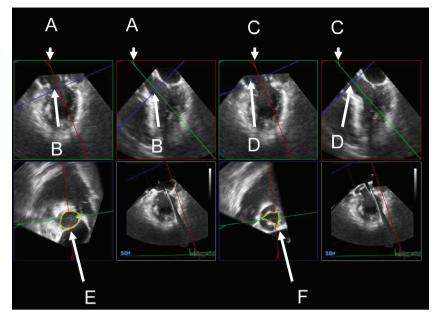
Three-dimensional transesophageal echocardiography measurements. Using a 6-beat gated, full-volume acquisition acquired with 3-dimensional transesophageal echocardiography midesophageal long-axis view, QLAB was used to perform planimetry of the left ventricular outflow tract area and aortic valve area. The frame was selected at the point of maximal aortic valve cusp separation. First, the *red* and *green* planes were aligned through the left ventricular outflow tract (A) and aortic valve (C). To measure the left ventricular outflow tract area, the *blue* plane (D) was aligned perpendicular to the left ventricular outflow tract (B) at the same distance from the aortic annulus as for the 2-dimensional measurement (typically 0.5 cm) and the area was measured with planimetry (E). To measure the aortic valve area, the *blue* plane was aligned perpendicular to the aortic valve leaflet tips and the area was measured with planimetry (F).
